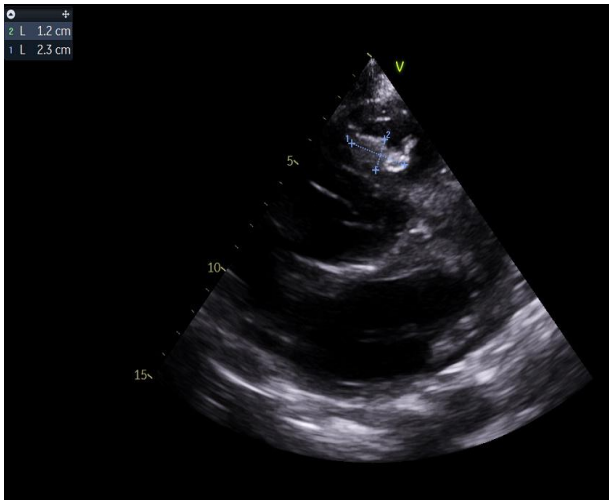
apical four-cavity section showing a hyperechoic filiform image arising on the IVS and floating in the RV (vegetation image)
